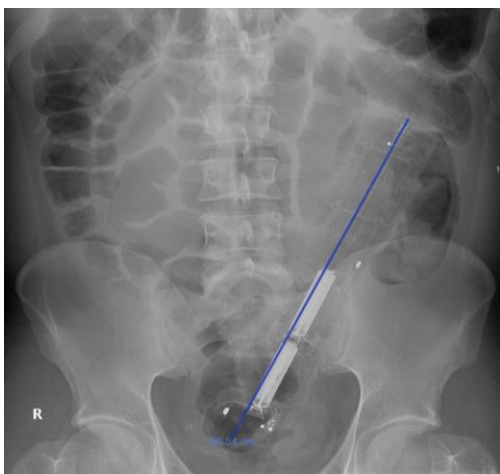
Abdominal radiograph revealing the retained remote control device.
